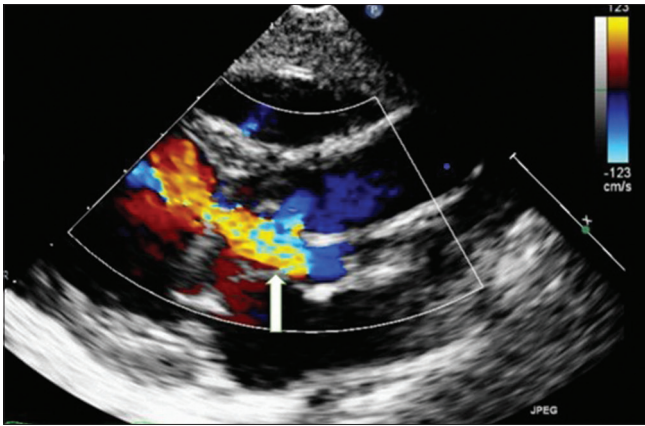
Transthoracic echocardiogram in the parasternal long-axis view showing aorto-left ventricular tunnel from left coronary–noncoronary commissure to left ventricle at the base of noncoronary cusp
